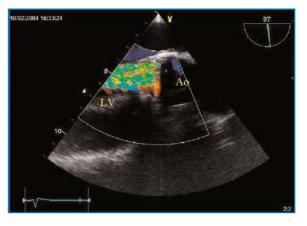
Significant aortic regurgitation (grade IV) in an HIV-infected patient, detected by color Doppler transesophageal echocardiography
